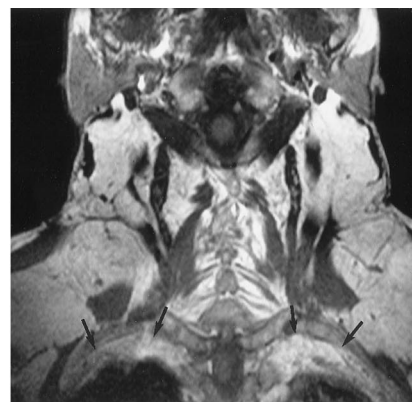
Coronal T1-weighted MR image (500/20) shows the presence of excess extrapleural fat bilaterally (arrows).
